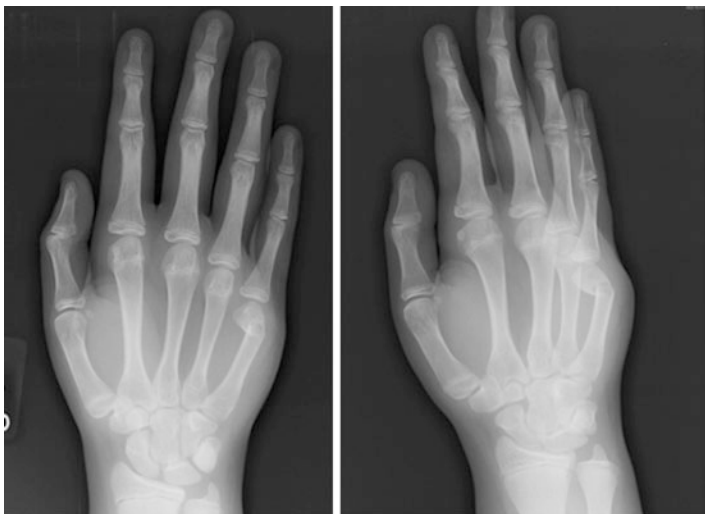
Radiographs of a fifth metacarpal fracture
